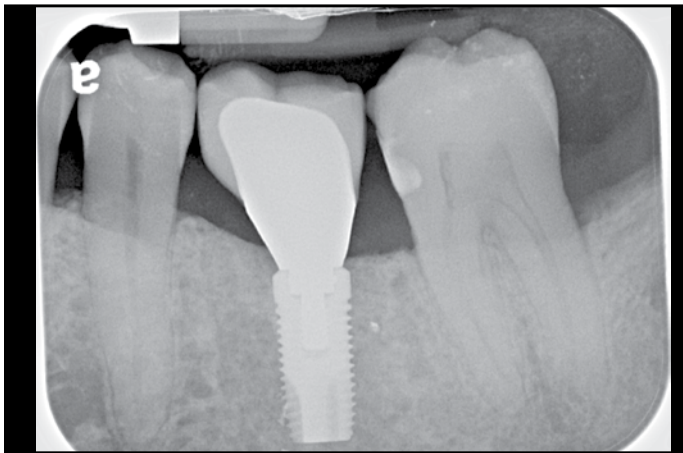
Radiograph of the final crown suggests good maintenance of bone levels at 4 months post-placement.
